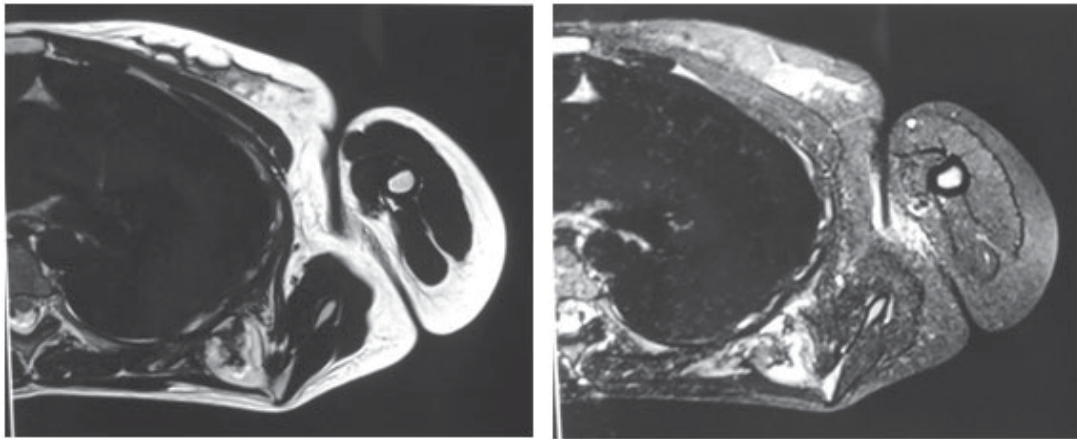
MRI images showing a pedunculated osteochondroma arising from medial and ventral border of scapula. A pre-operative CT scan(fig. 4) was done and a pedunculated osteochondroma was seen arising from ventral aspect of scapula. An excisional biopsy was planned under general anaesthesia. Patient was placed in prone position and an incision was given 2-3 cm medial to the medial border of scapula. Rhomboid muscle was splitted along its fibres and retracted to expose the lesion. A large bursa was covering the lesion and excised (Fig. 5). After excising the bursa, scapula retracted to expose the tumour along its whole length. Meticulous dissection was done to avoid injury to thoracic wall and pleura. Lesion was excised extraperiosteally from its base (Fig. 6).
